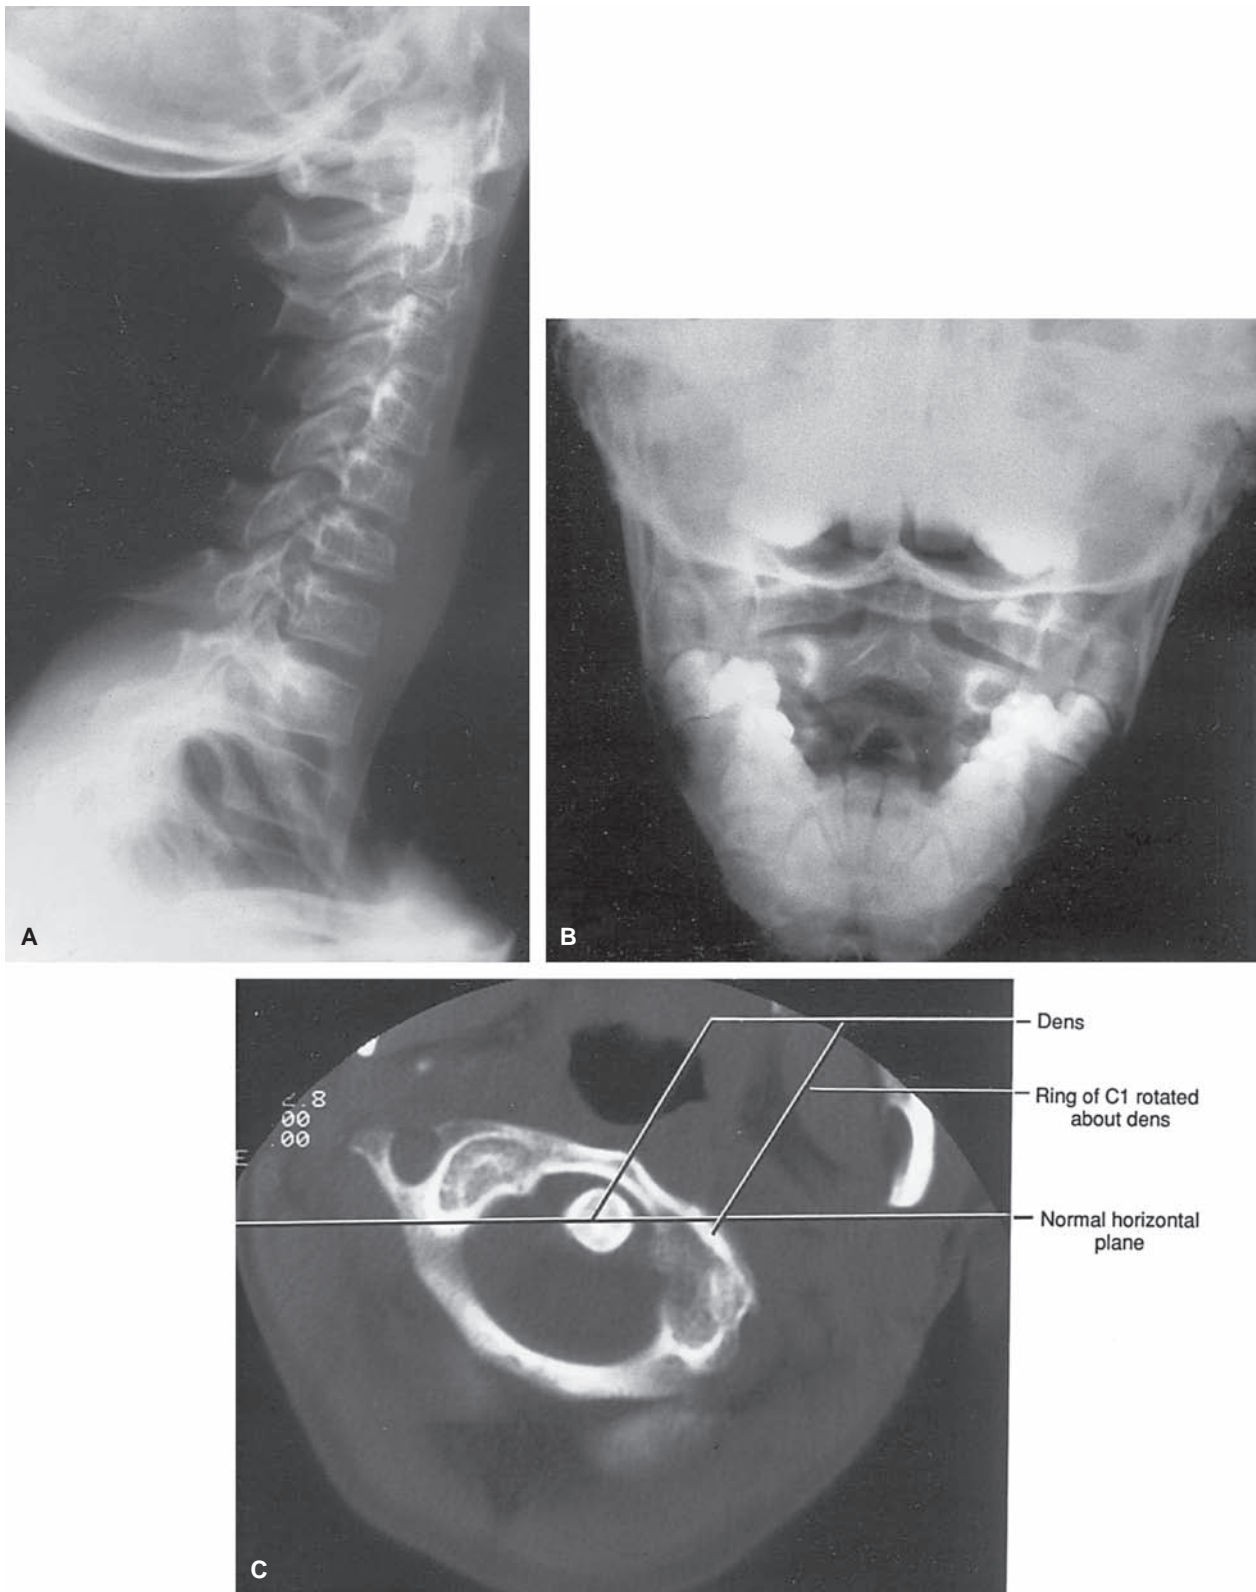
Rotary subluxation of C1 and C2. A: Grossly normal lateral neck radiograph in an 8-year-old child with rotary subluxation. B: Grossly normal open-mouth (odontoid) radiograph in an 8-year-old child with rotary subluxation. C: Computed tomographic (CT) scan demonstrating marked rotary subluxation of C1 clockwise around dens. Actual measurement was 22 degrees of rotation. (*continued*)
